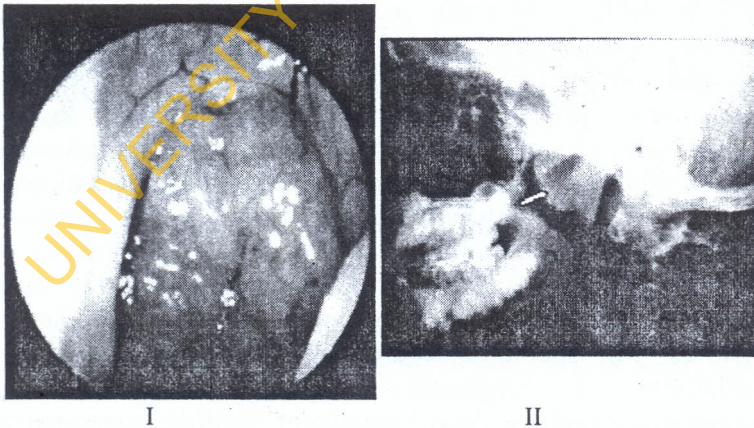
Enlarged nasopharyngeal adenoid: (I) showing endoscopic view: and (II) the soft tissue shadow in the nasopharynx on X-Ray postnasal space [arrowed]
